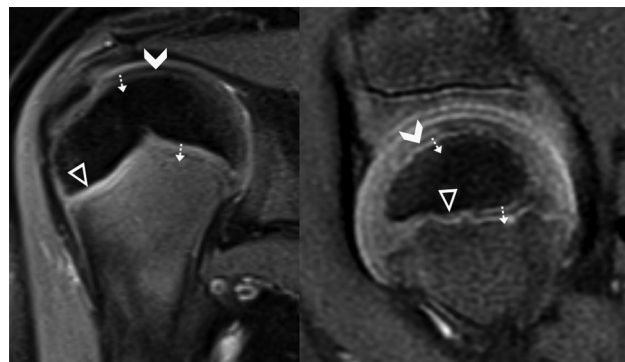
Direction of chondrocyte growth on intermediate-weighted fat-suppressed magnetic resonance images. Coronal image of the shoulder from an 8-year-old girl (left) and sagittal image of the hip from a 3-year-old boy (right) show regional primary (triangles) and secondary physes (chevrons). Tiny dashed arrows denote direction of chondrocyte growth, maturation, and apoptosis.
